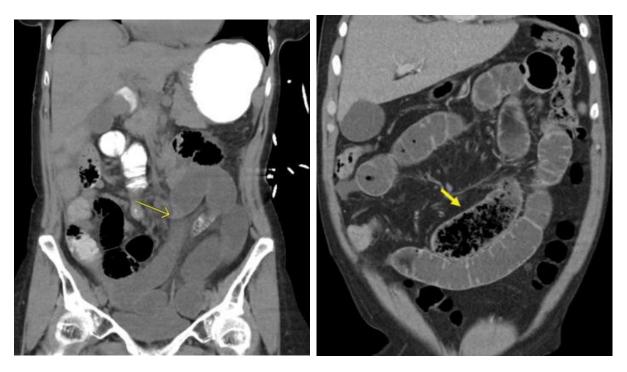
C.T. without IV contrast demonstrating a transition point (right) in the mid-abdomen with a smooth taper due to a postoperative adhesive small bowel obstruction and Coronal CT: "small bowel feces sign" (left) immediately proximal to a Crohn's stricture.<sup>[4]</sup>
